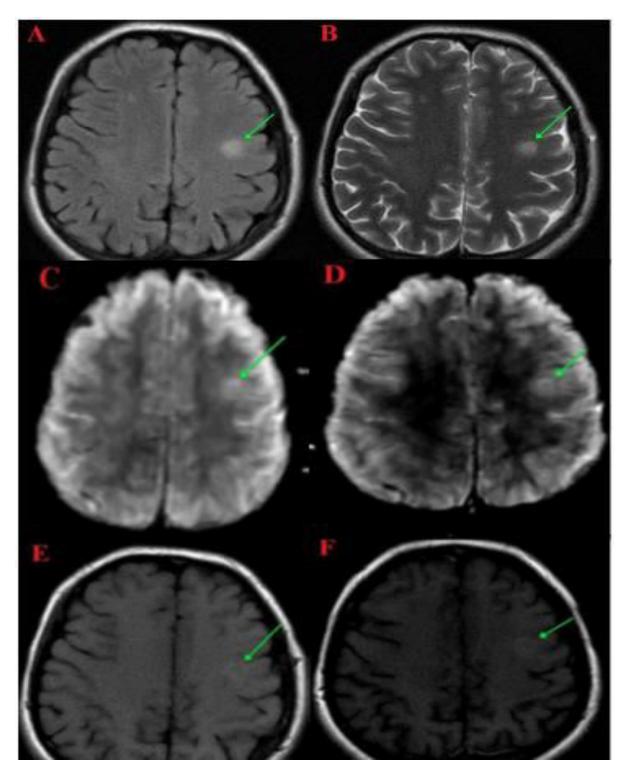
A 24-year-old male patient, presented with lumber weakness and numbness of three months duration. (The initial MRI) A & B): axial FLAIR and Axial T2WI:show left subcortical white matter hyperintense plaques, C): Axial pre contrast Susceptibility Weighted Images (SWI): Show white matter hyperintense plaques, D): Axial post contrast Susceptibility Weighted Images (SWI): Showwhite matter hyperintense plaques with central vein sign supporting diagnosis of MS, E & F): Axial T1WI (pre and post contrast study): The both show white matter isointense plaques that are difficult to be seen. The clinical and the radiological findings are consistent with inactive demyelinating disease (MS).
